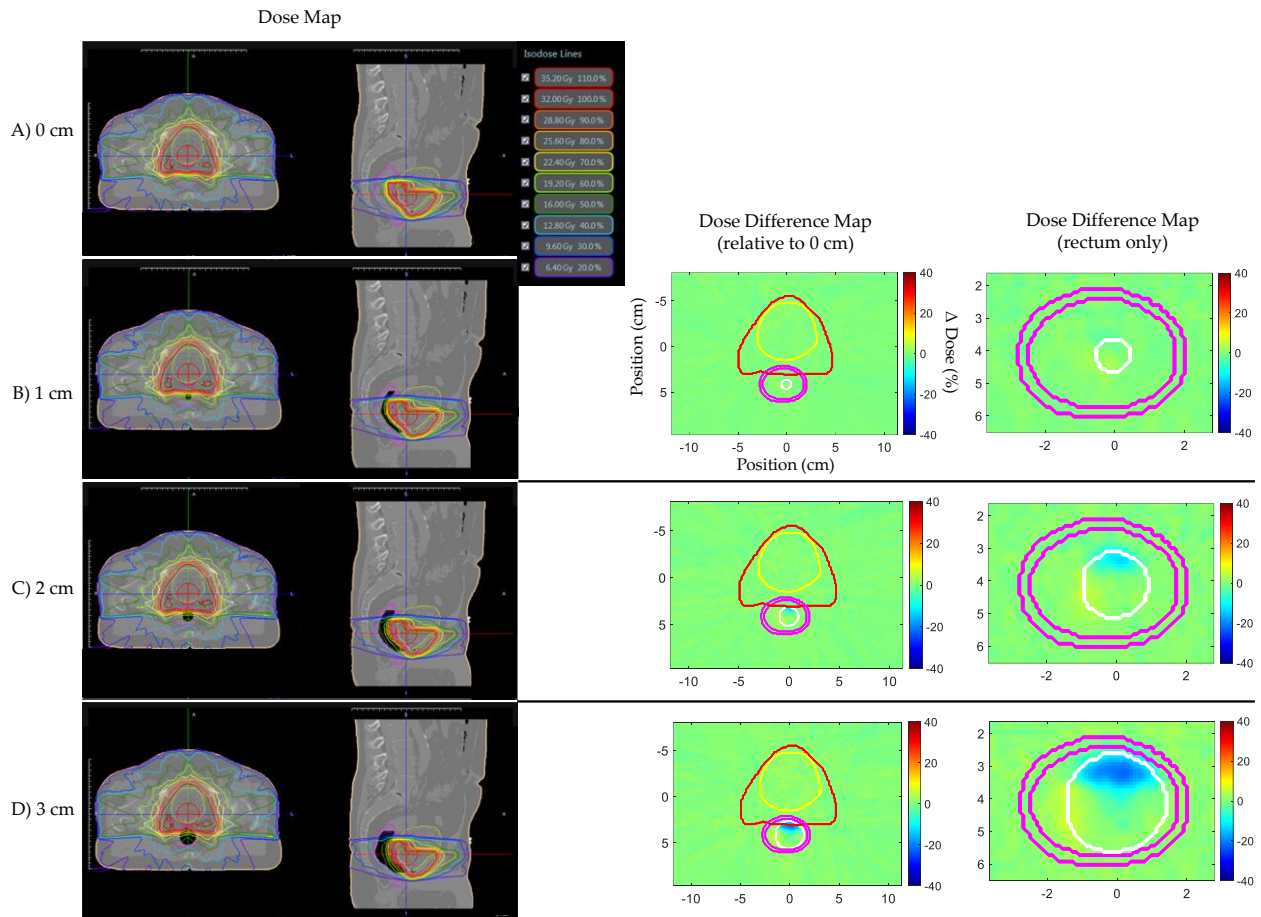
Prostate bed Patient A's clinical IMRT plan dose maps (overlaid on planning CT electron density map) and dose difference (Δ Dose(%)) maps for (A) 0, (B) 1, (C) 2, and (D) 3 cm artificial planning CT air cavity. Rectum dose difference maps show little to no dose change within the rectum for different air cavity sizes due to dose being uniformly spread and the electron return effect (ERE) being averaged-out by multiple opposing beams. Dose difference map planning CT contours displayed: Red—PTV; Yellow—bladder; Pink—rectum; White—artificial air cavity.
